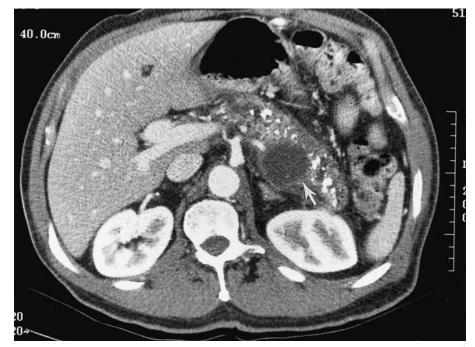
Chronic pancreatitis is best diagnosed with CT scan, which reveals the presence of calcifications, dilatated pancreatic duct, and pseudocysts (arrow). (Courtesy of Henry I. Goldberg, MD.)
